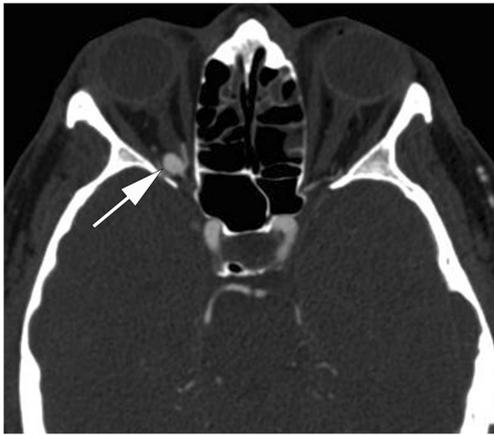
Postoperative CTA obtained 18 months after surgical obliteration of the DAVF disclosed that the aneurysm was unchanged in shape and size
